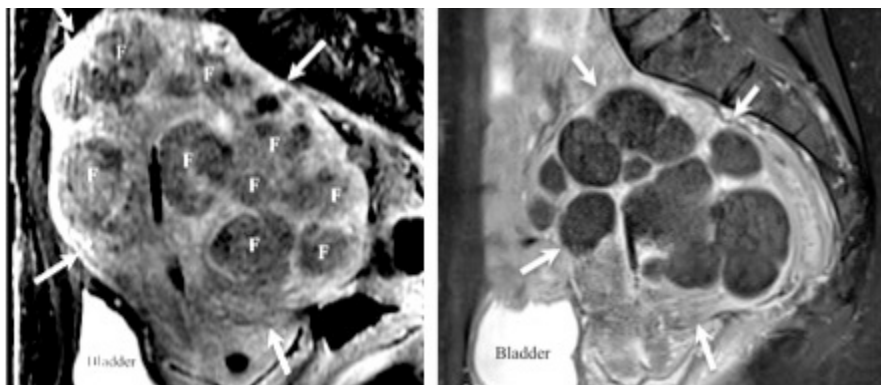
Pre-UAE MRI showed numerous fibroids denoted as "F". The fibroids became infarcted and no longer viable, seen as nonenhancing nodules of hyaline degeneration. The uterine volume reduced from 781ml to 349ml.
